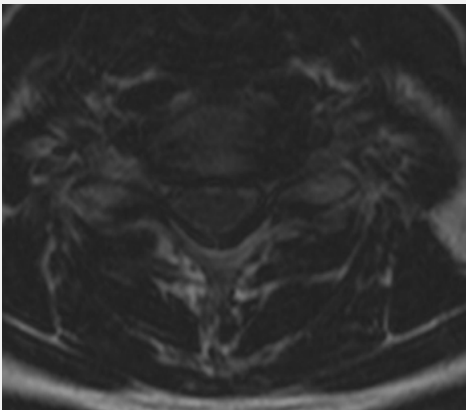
MRI showing left foraminal stenosis
